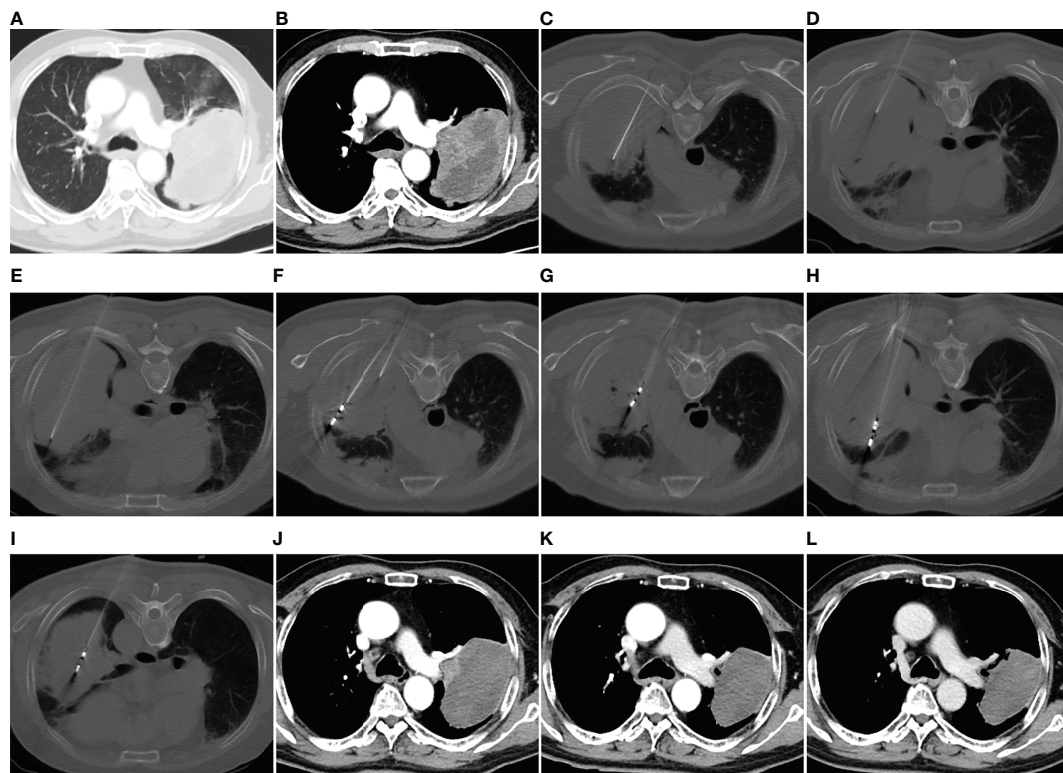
MWA + ITC treatment of a large squamous cell lung cancer in the left upper lobe of a 69-year-old man. Enhanced CT scan in the pulmonary window (A) and mediastinal window (B) showing a mass with a maximum diameter of 11.5 cm adjacent to the left pulmonary artery. (C–E) Direct injection of 40 mL aqueous solution containing 80 mg cisplatin into the mass *via* three 21-gage Chiba needles at a multisite. (F–I) MWA using four antennae at multisite and multisession with an ablation power of 60 W and a cumulative ablation time of 52 min. (J) Enhanced CT scan at 1-month follow-up after MWA + ITC showing an almost complete necrosis of the ablation zone. (K, L) Enhanced CT scan at 3- and 9-month follow-up after MWA + ITC showing gradually involuting fibrosis of the necrotic zone and no local residue. MWA, microwave ablation; ITC, intratumoral chemotherapy; CT, computed tomography.
